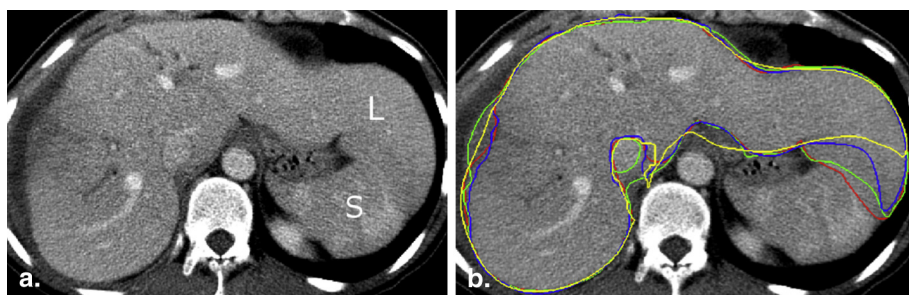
A 30-year-old woman with choledochal cyst. Original (a) and annotated (b). Axial computed tomography slice demonstrating discordance between four readers using manual and semiautomated liver segmentation methods. Reader-1 manual = red tracing, reader-2 manual = green tracing, reader-3 semiautomated = blue tracing, reader-4 semiautomated = yellow tracing. Discordance between readers is found at the interface between the liver (L) and the spleen (S), the liver hilum, and the peripheral segment 8-liver lesion. (Color version of figure is available online.)
